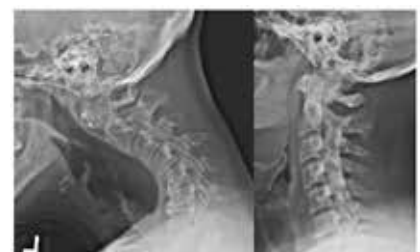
The left x-ray demonstrates a patient with cervical kyphosis, or an abnormal forward bend of the neck. The right x-ray shows a different patient with a more normal "lordotic" (ie, "backward") bend of the neck
